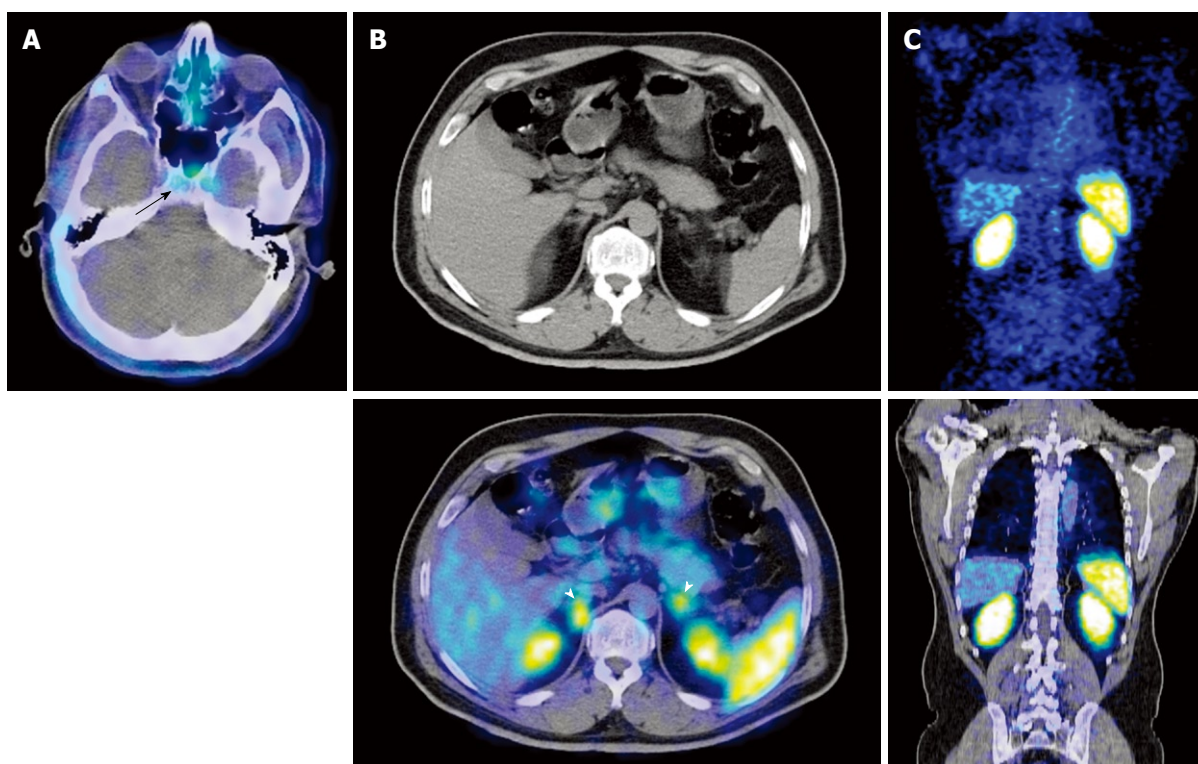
Examples of physiological areas of uptake in somatostatin receptor scintigraphy. A: Axial positron emission tomography (PET)/computed tomography (CT) of the base of skull demonstrates avid uptake in the pituitary fossa (black arrow) corresponding to physiological uptake in the pituitary gland; B: Axial CT and PET/CT of the abdomen demonstrates physiological uptake in the adrenals glands (white arrowheads); C: Coronal PET and PET/CT sections demonstrate avid tracer uptake in the kidneys and spleen.
